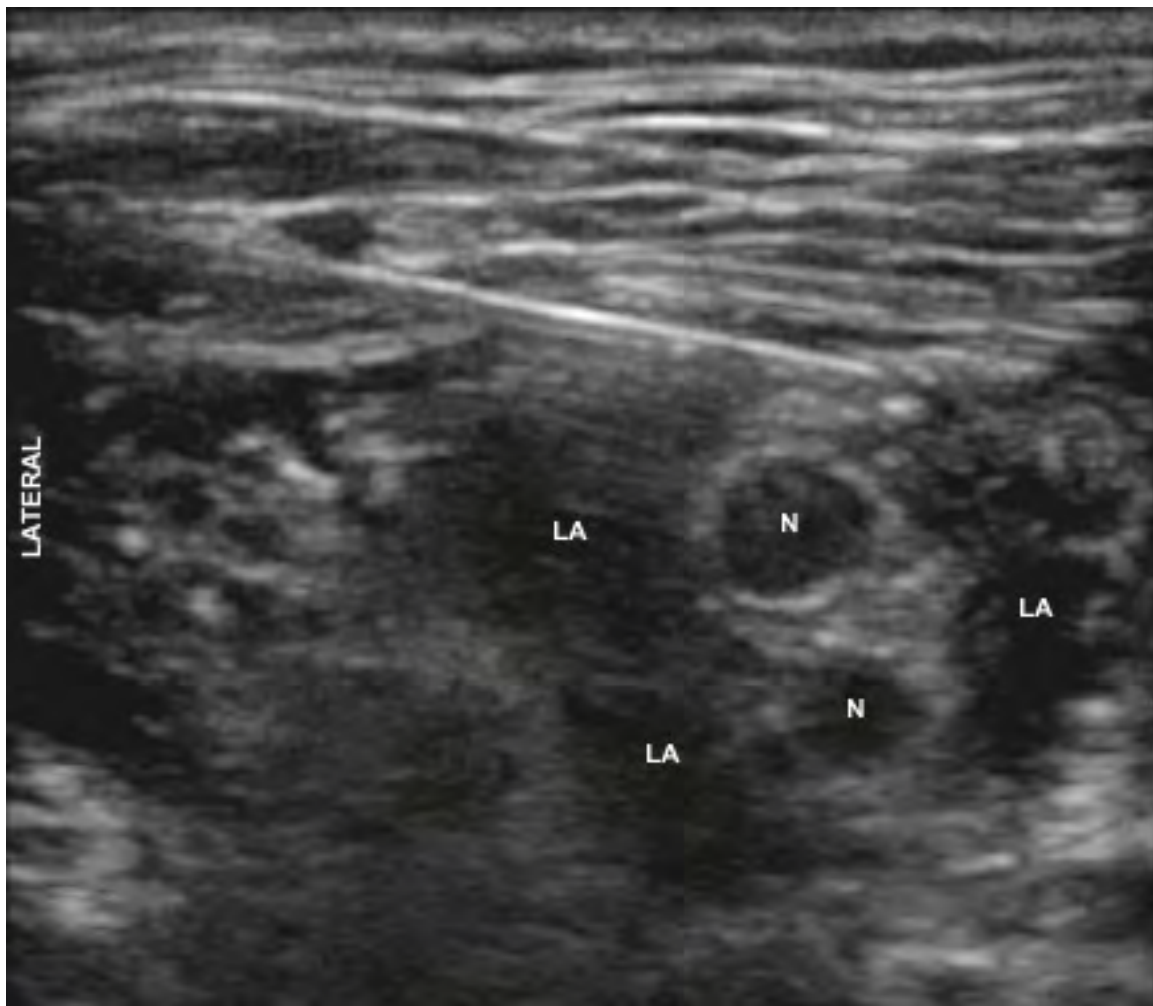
Ultrasound view of areas of local anesthetic (LA) volume deposition surrounding the brachial plexus at the level of the interscalene groove. Note the circumferential enhancement of the brachial plexus nerves (N) after local anesthetic deposition. The peripheral block needle is seen here as a hyperechoic linear structure positioned above the brachial plexus.
